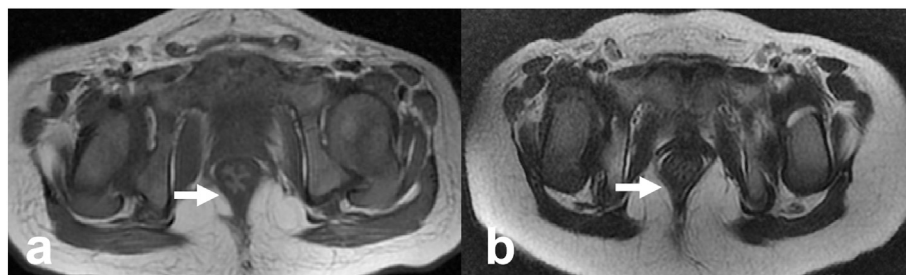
Sphincter muscle complex in axial T2WI MR images. a. Well-developed sphincter muscle complex (white arrow). b. Underdeveloped sphincter muscle complex (white arrow).
